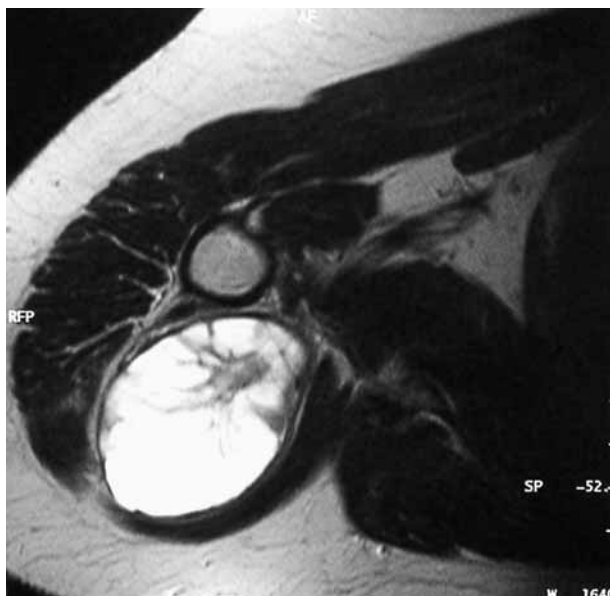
Magnetic resonance imaging (MRI) on axial view of the shoulder showing a 4 cm × 6 cm mass with high signal intensity on T2-weighted sequence.
